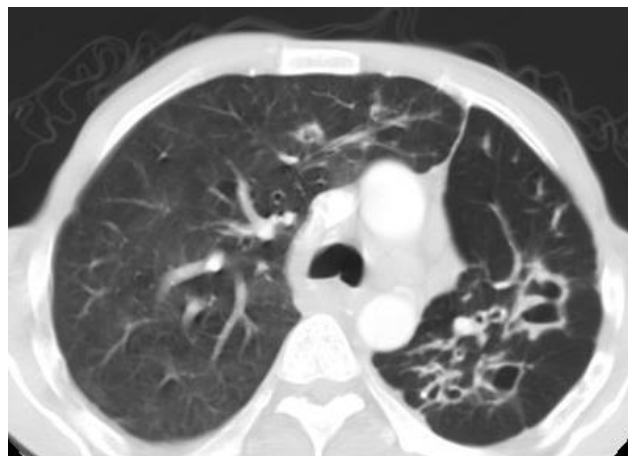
HRCT of relapsed patient with combined cystic and traction bronchiectasis.
